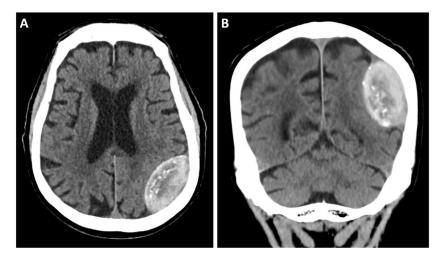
Unenhanced CT of the head, showing axial (A) and coronal (B) images, reveals a large, heterogeneous hyperdense collection in the left parietal convexity, without subjacent parenchymal edema. There is local mass effect on the brain parenchyma, but no midline shift. No calvarial fractures or scalp contusions are noted.
